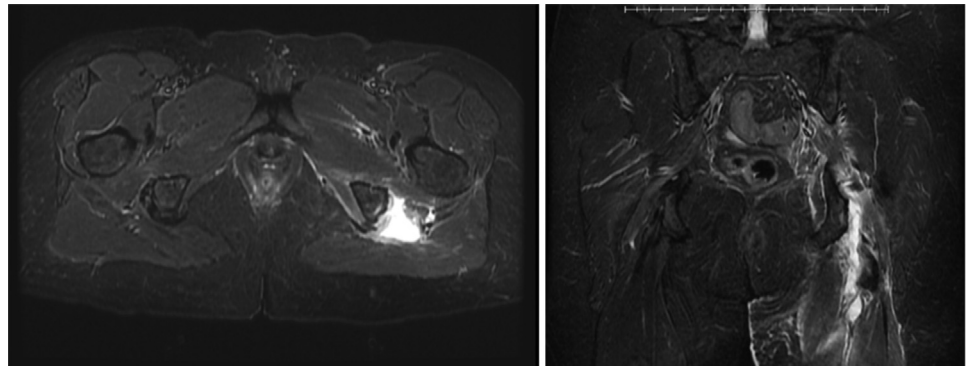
Axial and coronal T2 MRI sequences with fat saturation demonstrated a left-sided Type 3 injury with complete avulsion of both the conjoint and semi-membranosus tendons with greater than 2 centimeters of retraction. Edema is evident at the ischial tuberosity with bare tendon footprints.
